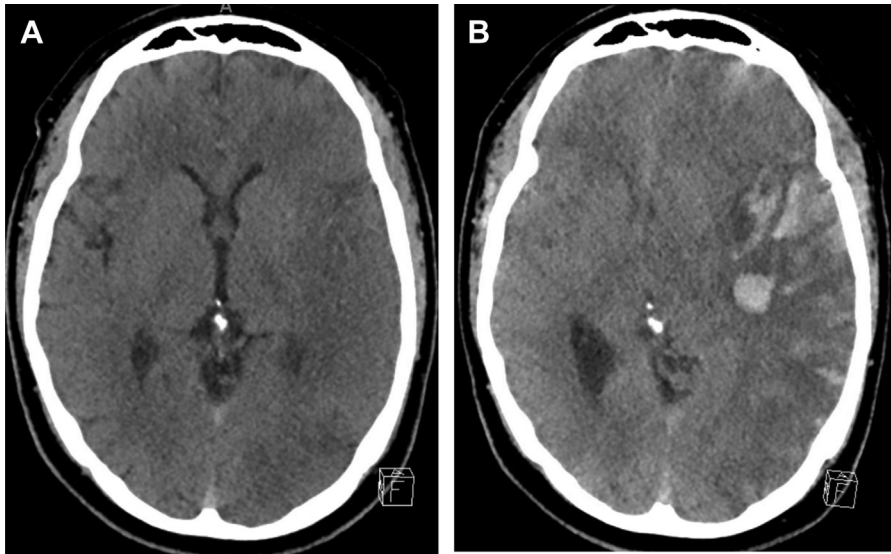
(A): Noncontrast head CT showing early infarct signs in the left MCA territory (B) Noncontrast head CT showing hemorrhagic conversion within 24 hours of first head CT. Note that the ECASS score here would be PH1 using definitions in [Table 3A](#) and the Heidelberg Bleeding Classification would be 1cPH1 using definitions in [Table 3B](#). (Courtesy of The University of New Mexico, Albuquerque, NM.)
